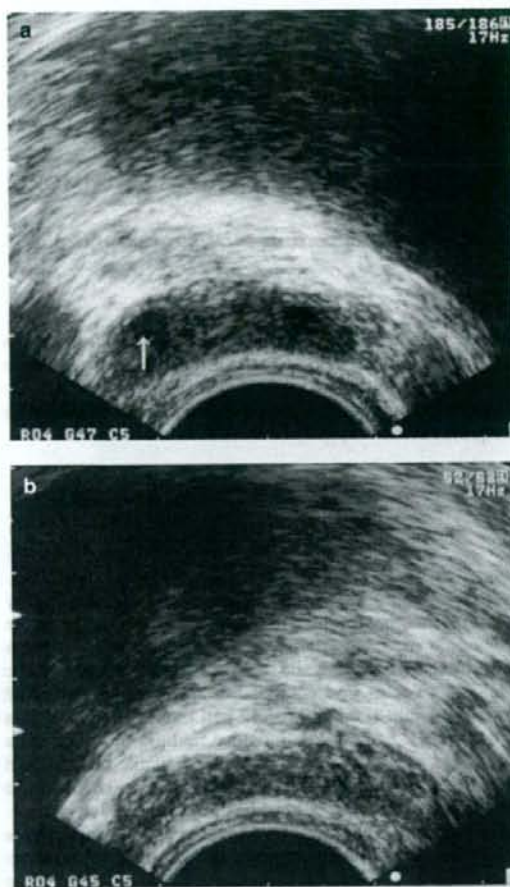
Seminal vesicle images by transrectal ultrasonography (case 1). (a) The right-side seminal vesicle was enlarged and dilated with multicystic changes. Arrows indicate cystic changes. (b) The left-side seminal vesicle was not dilated.
